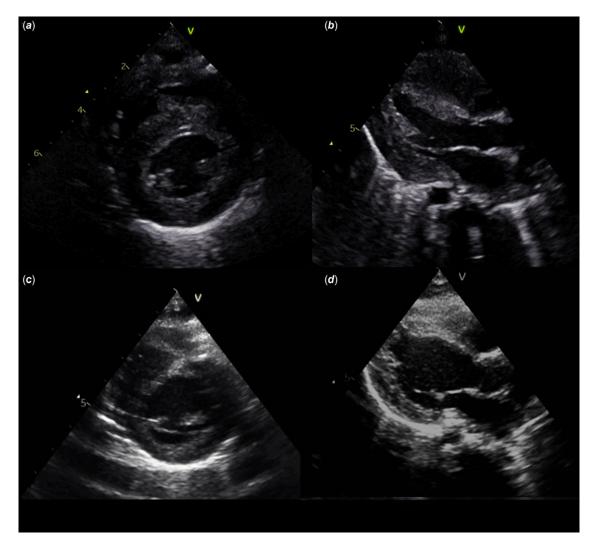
a and b - left ventricular (LV) hypertrophy (parasternal short axis and parasternal long axis, respectively); c and d - normal LV dimensions (PSAX and PLAX, respectively).
